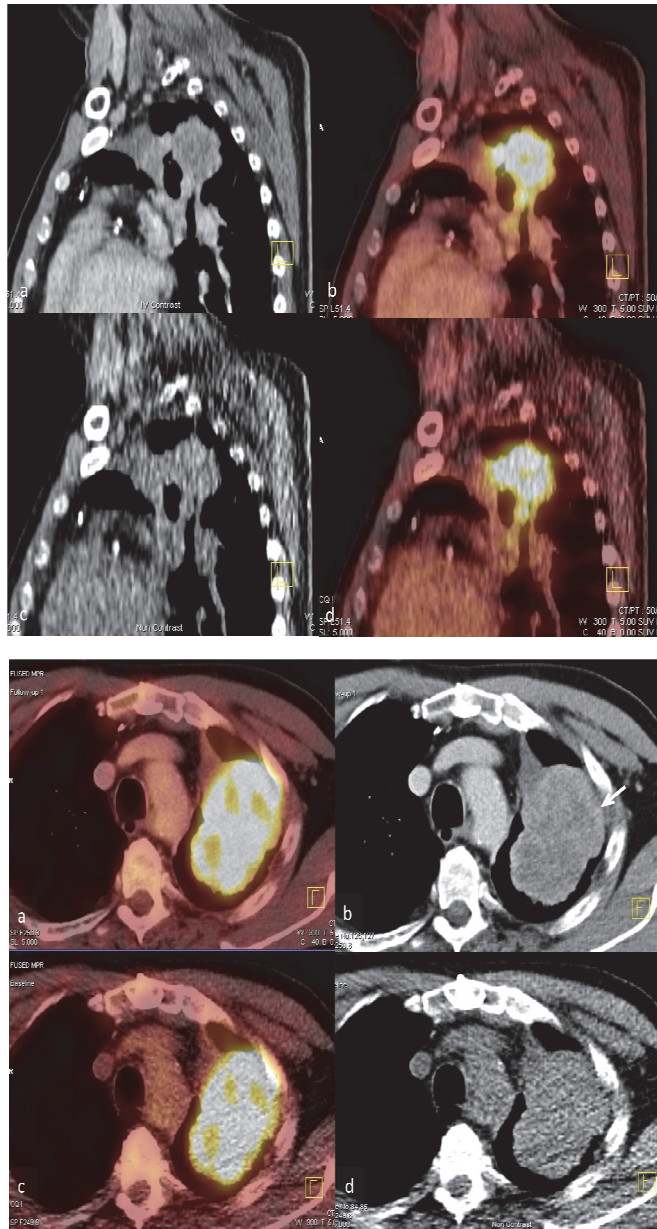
FDG PET/CT study of a 56 year old man with carcinoma of the left lung. FDG PET study in sagittal (top) and axial (bottom). Top row (a and b) demonstrate PET/CT study with intravenous contrast administration and bottom row (c and d) demonstrate FDG PET/CT with low dose non contrasted CT. Intravenous contrast sharply delineating tumour outline ( white arrow axial CT image) excluding thoracic wall invasion and vascular involvement.
